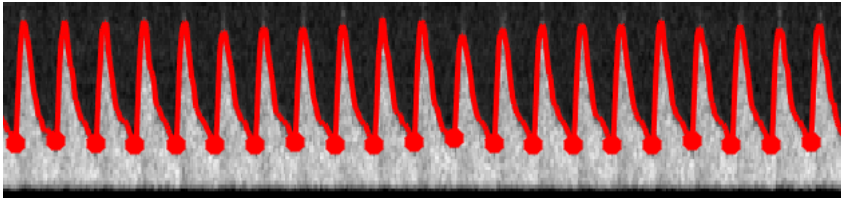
NeoDoppler spectrum for a healthy infant presented by the Earlybird software.
